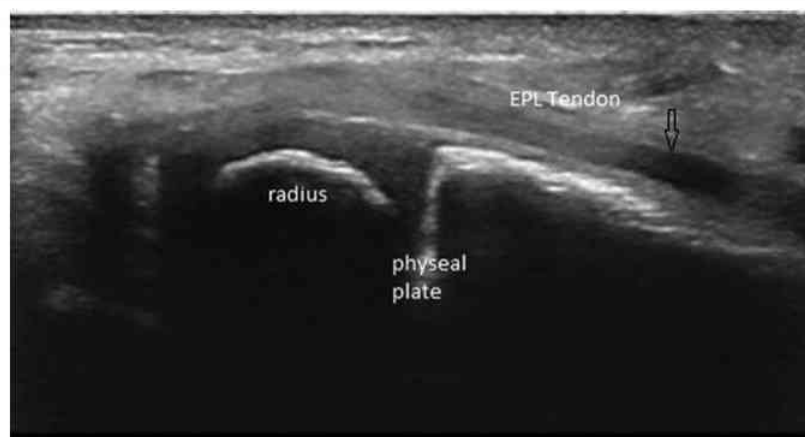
Longitudinal intraoperative sonographic view of the radius and the EPL tendon. Nail is not visualized in this plane. EPL=extensor pollicis longus.
